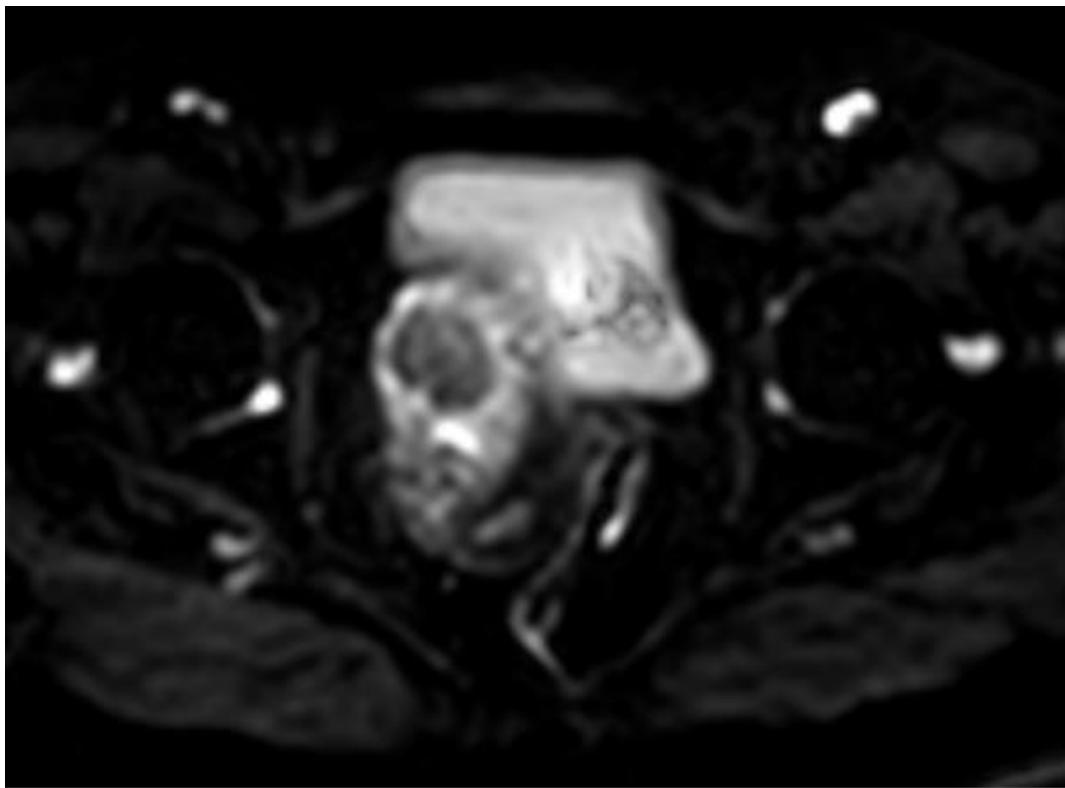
Axial diffusion-weighted MRI sequence demonstrating slight diffusion hyperintensity (Case 1).
